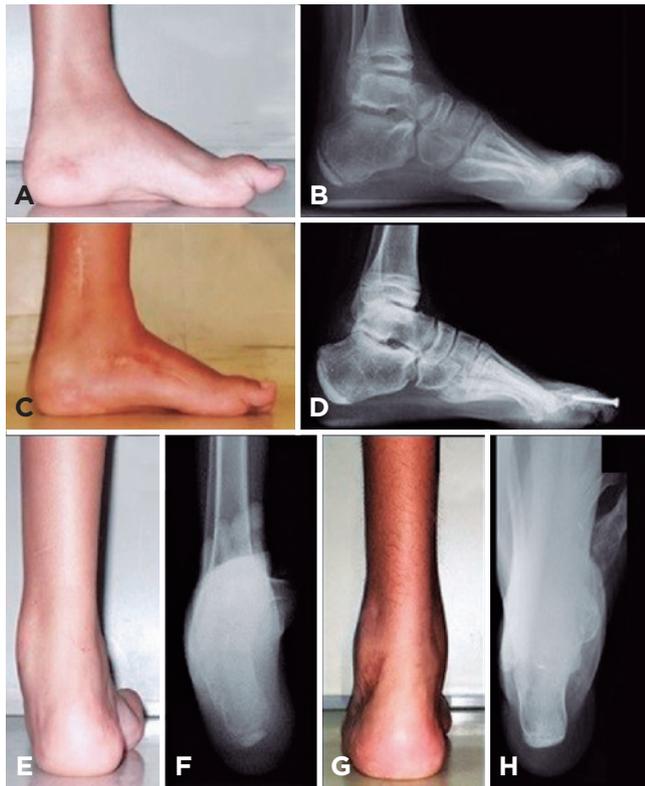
According to these clinical and radiographic images of the left foot and ankle of patient 12, the main deformities in the preoperative period were significantly corrected after surgery. Note the decrease in medial arch height before (4A) and 48 months after surgery (4C), which can also be seen in pre- (4B) and postoperative (4D) lateral weight-bearing radiographic images. Also note the correction of varus deformity of the hindfoot by comparing the pre- (4E) and postoperative (4G) clinical images. The correction can be better appreciated by comparing pre- (4F) and postoperative (4G) radiographic images in the axial leg-foot view. (Source: SAME Santa Casa de São Paulo).
